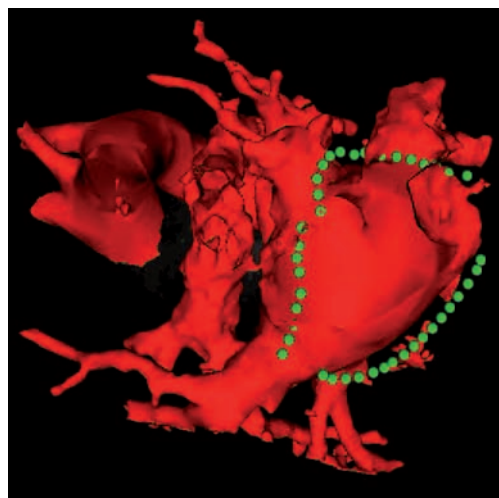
Magnetic resonance imaging (MRI) view of the left atrial endocardial surface (red) with the location of linear ablation points shown (green). The ablation points were marked onto the surface using hybrid X-ray/MRI registration technology during the course of the intervention.
